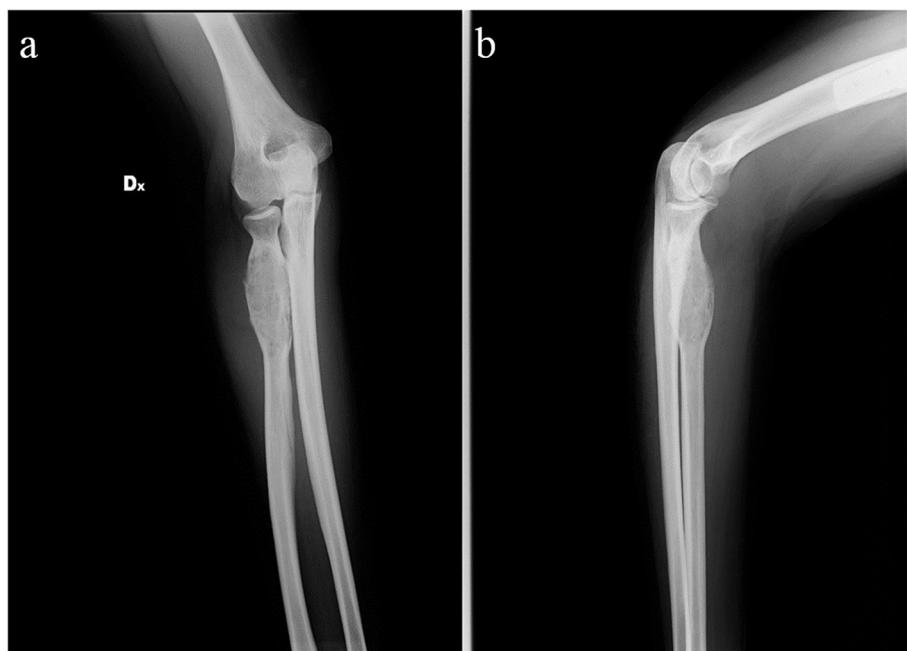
Postoperative radiographs of the right proximal radius after curettage of the lesion and filling the bone cavity with cement.
